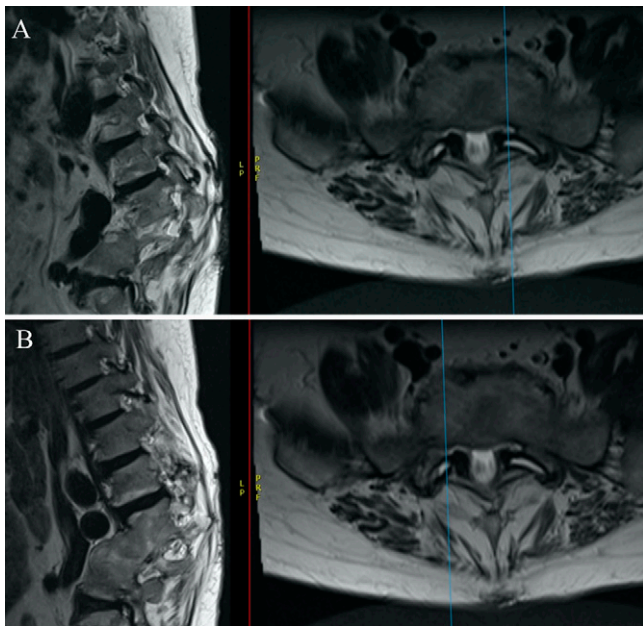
Preoperative sagittal MRI of lumbar spine without contrast. At L5–S1, there is disc bulge, facet hypertrophy, and ligamentum flavum thickening causing severe bilateral foraminal stenosis and moderate to severe spinal canal stenosis. A: Left-sided foraminal stenosis at L5–S1. B: Right-sided foraminal stenosis at L5–S1. *Blue lines* show the plane of the sagittal view (left and right foramen).
